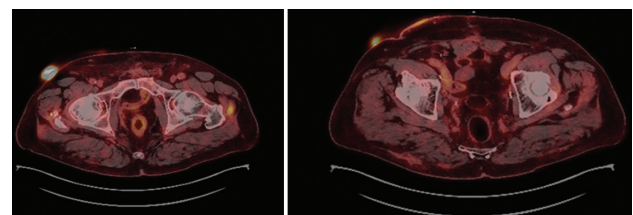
Positron emission tomography-computed tomography images obtained after two cycles of enfortumab vedotin therapy
